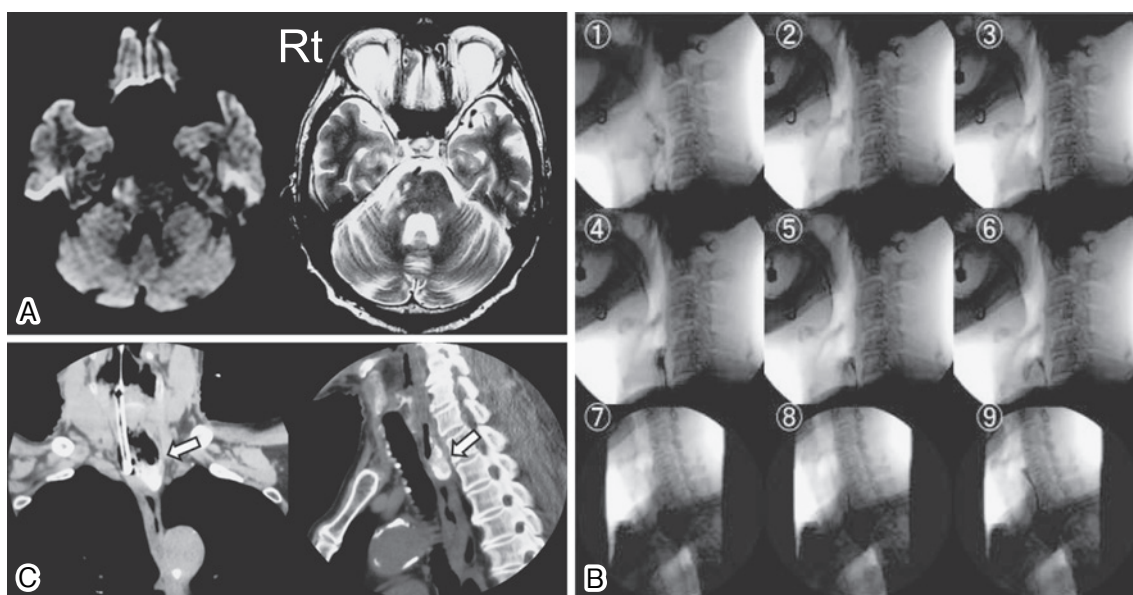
A: A brain magnetic resonance imaging scan showing a distinct signal in the region of the pontomedullary junction, adjacent to the pons, in a diffusion-weighted image (left), and a distinct, but weaker, signal in the same region on the T2-weighted image (right). B: Videofluorography images, obtained 13 days after admission, showing that contrast medium-labeled, gel-based food enters the esophageal area and returns to the esophageal orifice instead of moving to the stomach (1–6), as demonstrated by the deposition of the contrast medium in the Zenker's diverticulum (7–9), while the bolus is partially passed down to the lower esophageal area. C: A chest computed tomography scan showing the presence of the Zenker's diverticulum in the right portion (arrow) of the upper esophagus.
